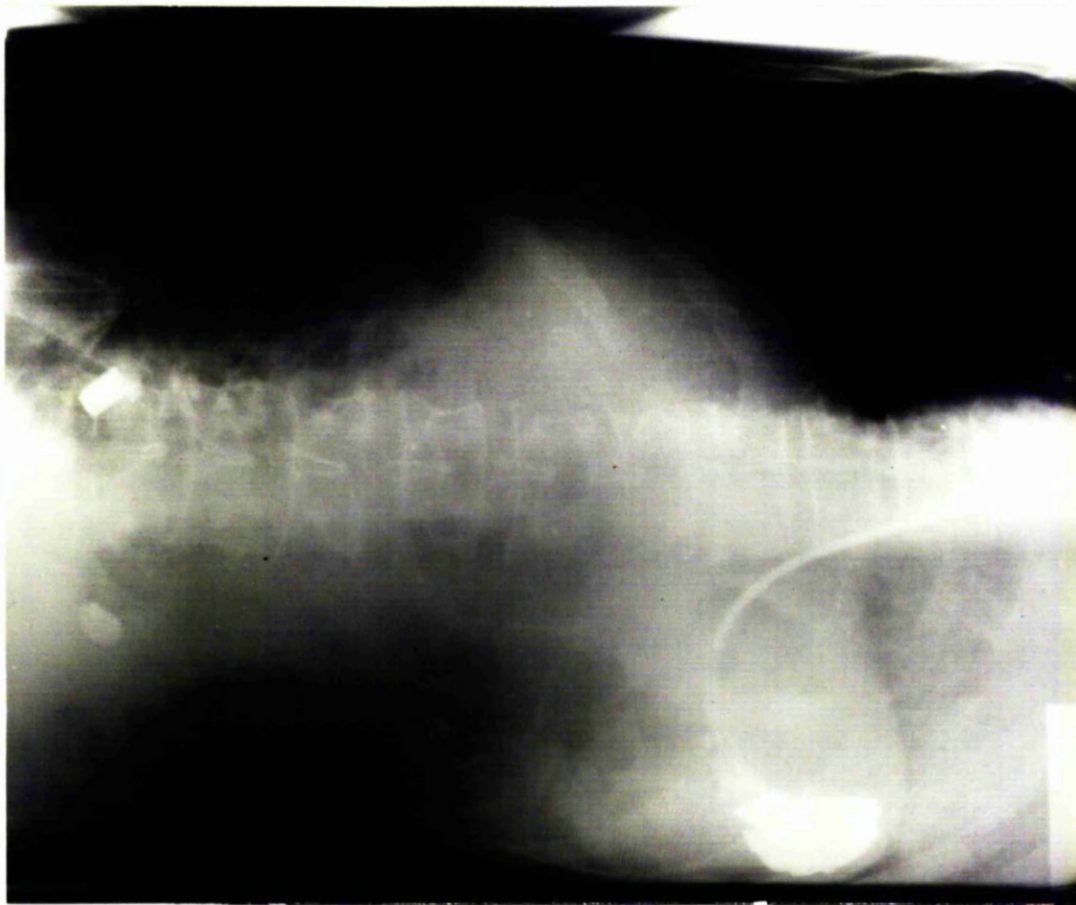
A radiograph of the stomach with the patient lying on his left side. The nasogastric tube dips down into the resting pool of gastric juice in the most dependent part of the stomach. The tube was in this position in 10 of the 42 subjects studied (24%).
